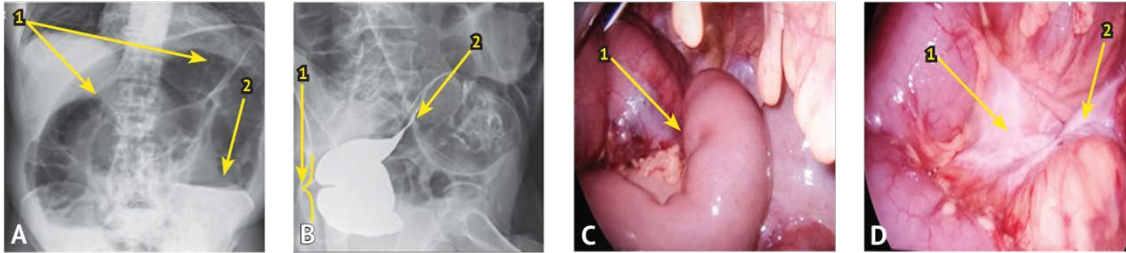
First admission. A — plain X-ray image of the abdominal cavity. A sharply swollen loop of the sigmoid colon (arrows 1) with a fluid level (arrow 2) is revealed; B - irrigoscopy. The distal parts of the sigmoid colon are contrasted (arrow 1). The “beak” symptom is clearly defined (arrow 2); C — intraoperative photo of sigmoid colon volvulus before straightening (arrow 1 — torsion zone); D — intraoperative photo of the sigmoid colon after the volvulus has expanded (arrow 1 — enlarged dilated mesentery, arrow 2 — narrow base of the mesentery and strangulation zone)
